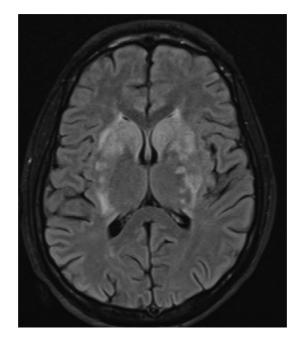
Axial Brain MRI with T2 FLAIR depicting hyperintense signal in bilateral basal ganglia.
